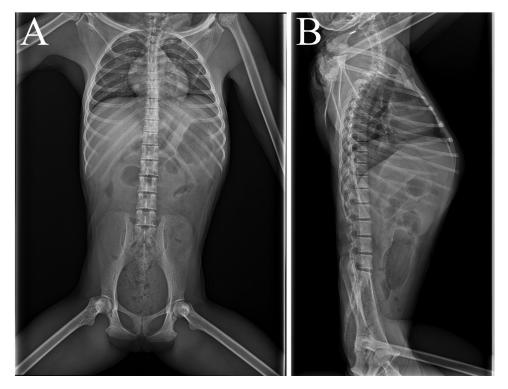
(A) ventrodorsal and (B) laterolateral x-rays of white-handed gibbon with Francisella tularensis subsp. holarctica infection show mild intestinal dilatation.
